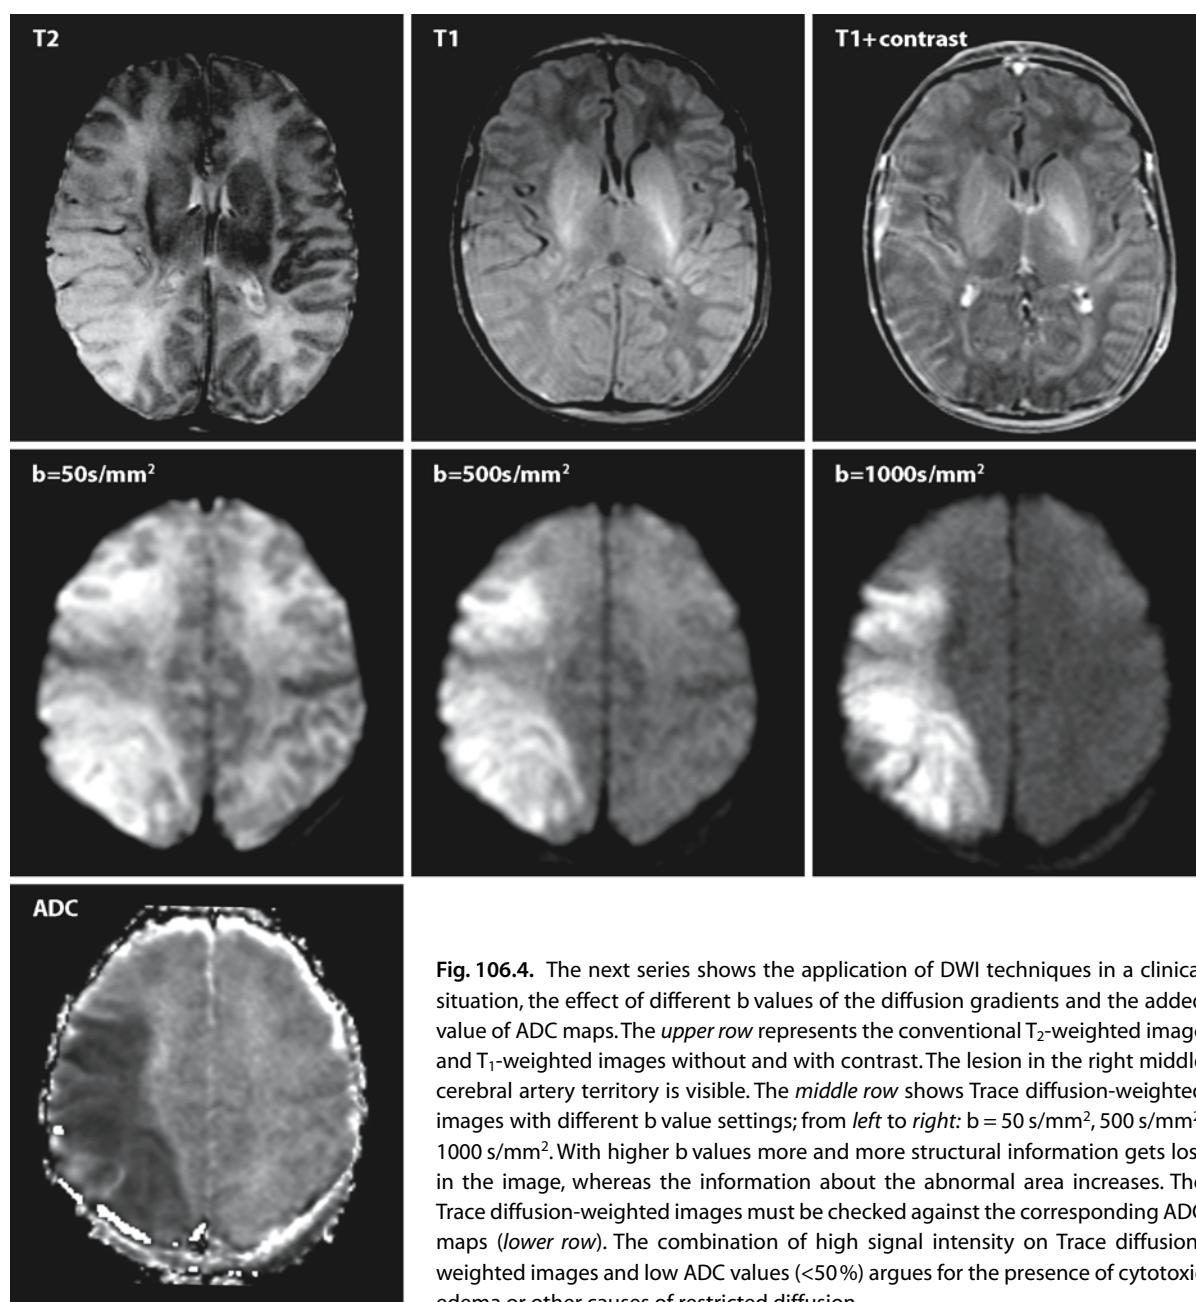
The next series shows the application of DWI techniques in a clinical situation, the effect of different b values of the diffusion gradients and the added value of ADC maps. The *upper row* represents the conventional T₂-weighted image and T₁-weighted images without and with contrast. The lesion in the right middle cerebral artery territory is visible. The *middle row* shows Trace diffusion-weighted images with different b value settings; from *left to right*: b = 50 s/mm², 500 s/mm², 1000 s/mm². With higher b values more and more structural information gets lost in the image, whereas the information about the abnormal area increases. The Trace diffusion-weighted images must be checked against the corresponding ADC maps (*lower row*). The combination of high signal intensity on Trace diffusion-weighted images and low ADC values (<50%) argues for the presence of cytotoxic edema or other causes of restricted diffusion
